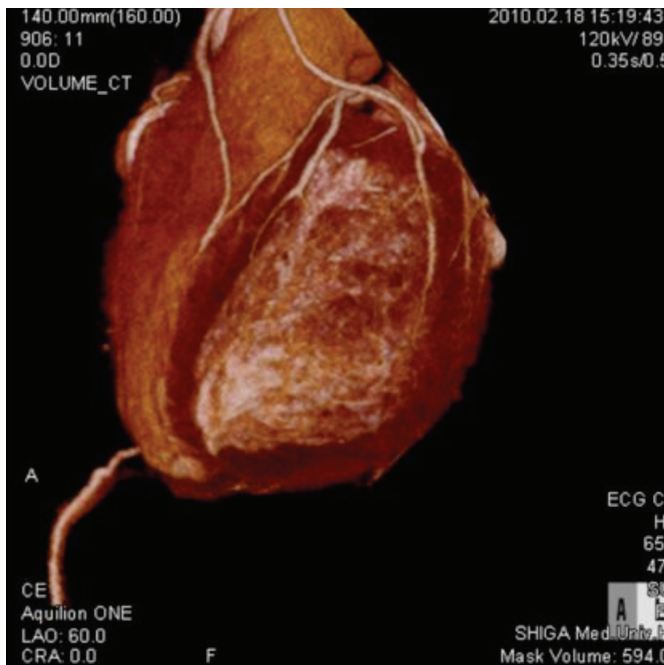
Postoperative coronary computed tomography demonstrated good patency of the all-arterial grafts. The right internal mammary artery was anastomosed to the left anterior descending, the left internal mammary artery to the obtuse marginal branch, and the right gastroepiploic artery to the posterior descending artery.
